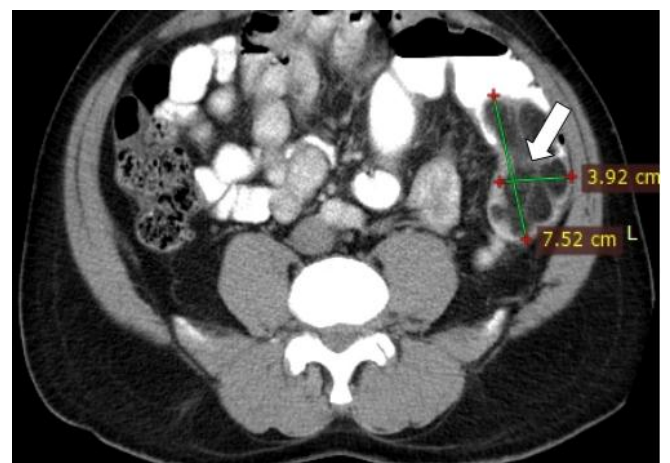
Axial CT image of the abdomen showing measurements of the colonic lipoma(Arrow).
